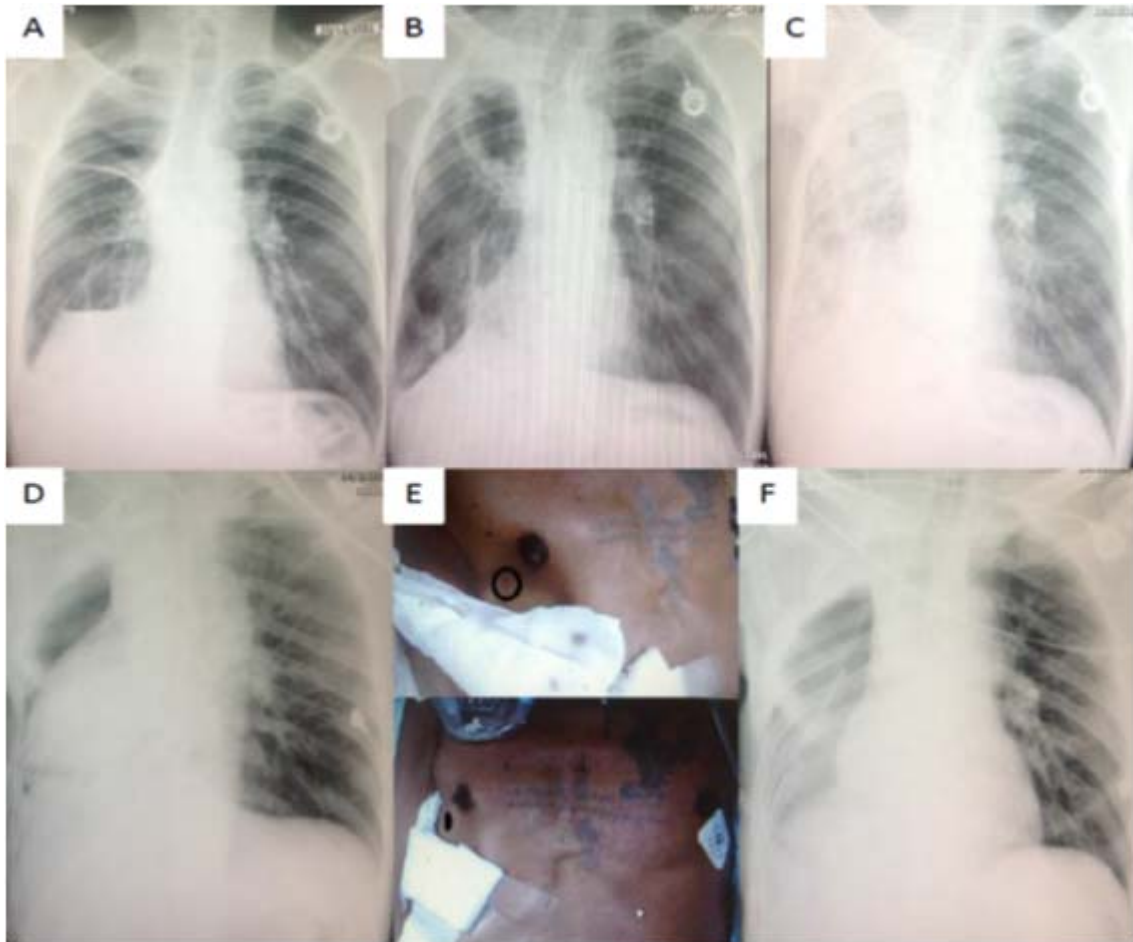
(1A) Chest radiography after right upper lobe and right middle lobe lobectomies 2 years before admission shows decreased volume of the right lung and right diaphragmatic elevation, (1B) Chest radiography 4 months before admission shows a cavity at right upper lung field, (1C) Chest radiography during the antibiotic treatment shows right lung infiltration with a large abscess, (1D) Immediate postoperative chest radiography shows the heart displaced into the right hemithorax, (1E) The point of maximum cardiac impulse (PMI) shifts to the right hemithorax (black circle demonstrates PMI.), (1F) Post-rethoracotomy chest radiography shows the heart has returned to the normal position.
